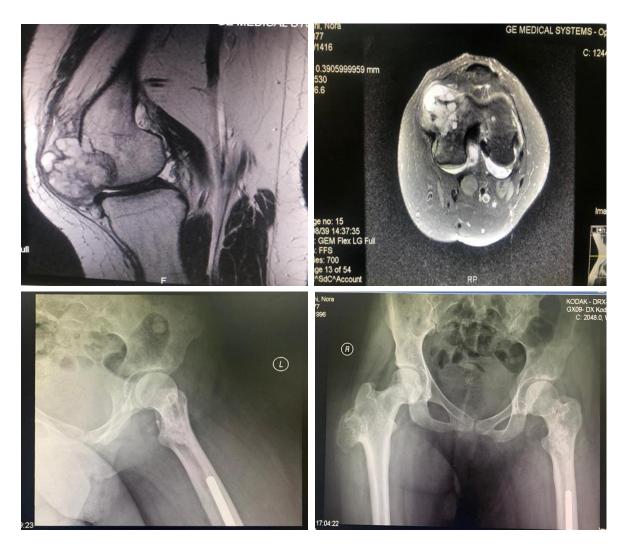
(a,b,c and d):- Radiographic studies shows chondrosarcoma in the leftdistal femur (a and b) and chondroma in the left proximal femur (c) and right proximal femur osteochondroma (d).
